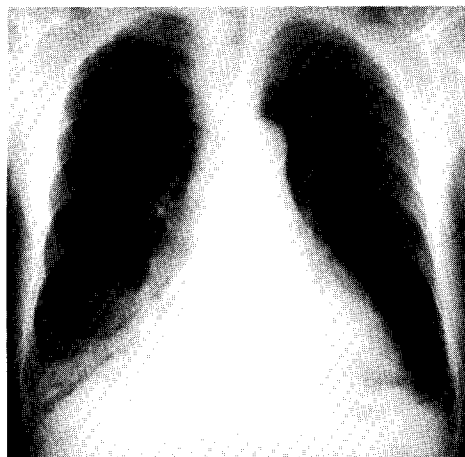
Chest roentgenogram. The cardiac shadow is enlarged and an interstitial infiltrate (shadow) is seen in the right lower lung field.
